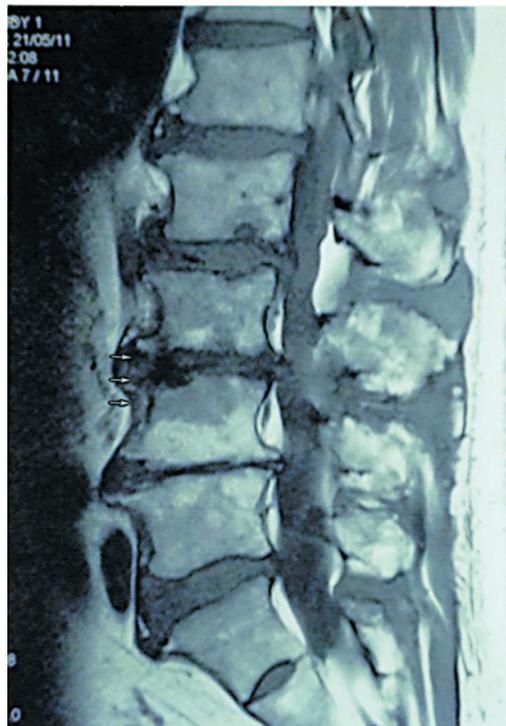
MR imaging (T₁-weighted MR images) showed L3/L4-level APVS (CASE 1)(→)
